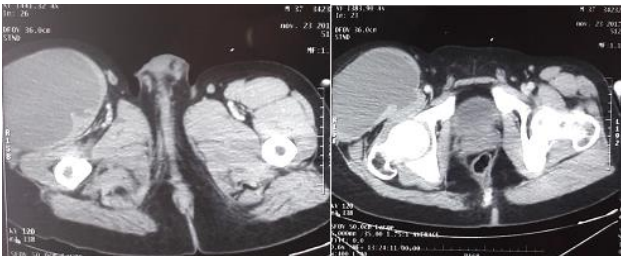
CT images showing the extent of the muscle injury.
